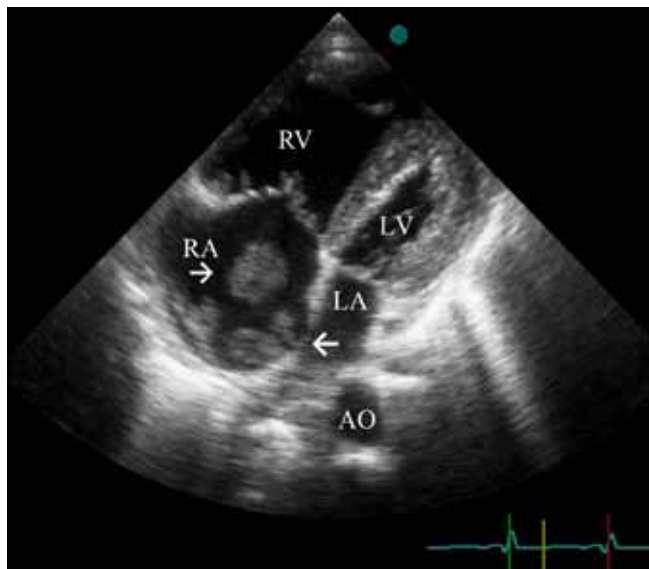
Two-dimensional echocardiographic image, depicting the apical four-chamber view. The top arrow shows a mobile in situ thrombosis with a narrow stalk, and the bottom arrow shows an immobile in situ thrombosis. AO, Aorta; LA, Left atrium; LV, Left ventricle; RA, Right atrium; RV, Right ventricle
